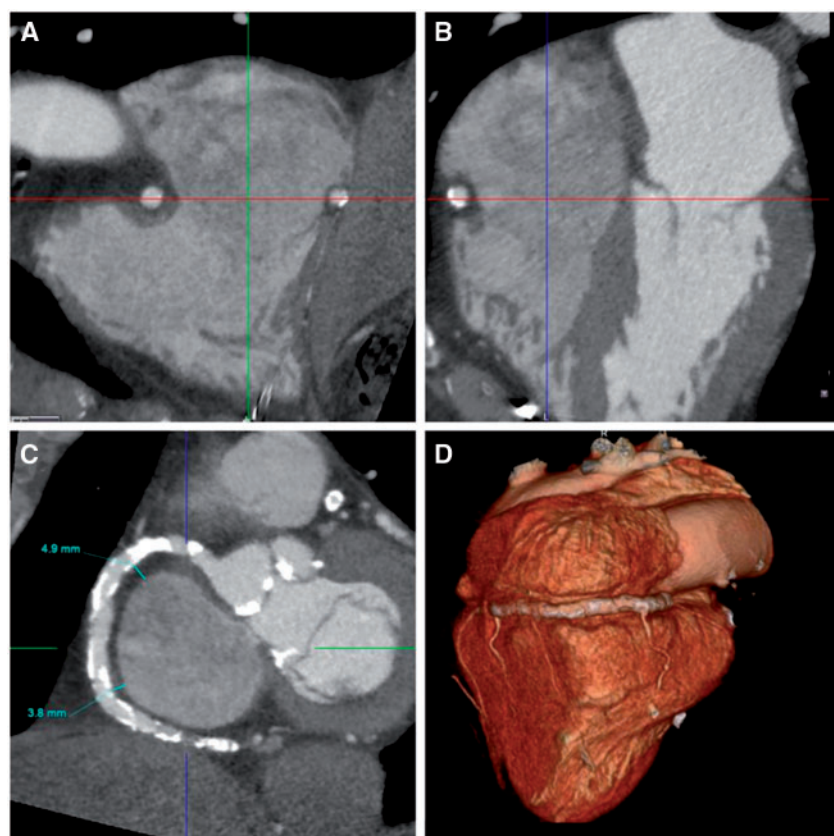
Assessment of the distance between the right coronary artery (RCA) and the tricuspid valve annulus. The long-axis 2- and 4-chamber views (A and B) were aligned to reconstruct a short-axis view of the tricuspid valve annulus (C). At the level of the anterior and posterior tricuspid valve leaflet insertions, the distance to the RCA was assessed. Panel D shows the volume rendered reconstruction demonstrating the course of the RCA completely along the tricuspid valve annulus. (from van Rosendael PJ, Kamperidis V, Kong WKF, van Rosendael AR, van der Kley F, Ajmone Marsan N, Delgado V, Bax JJ. Computed tomography for planning transcatheter tricuspid valve therapy. See pages 665–674.)
